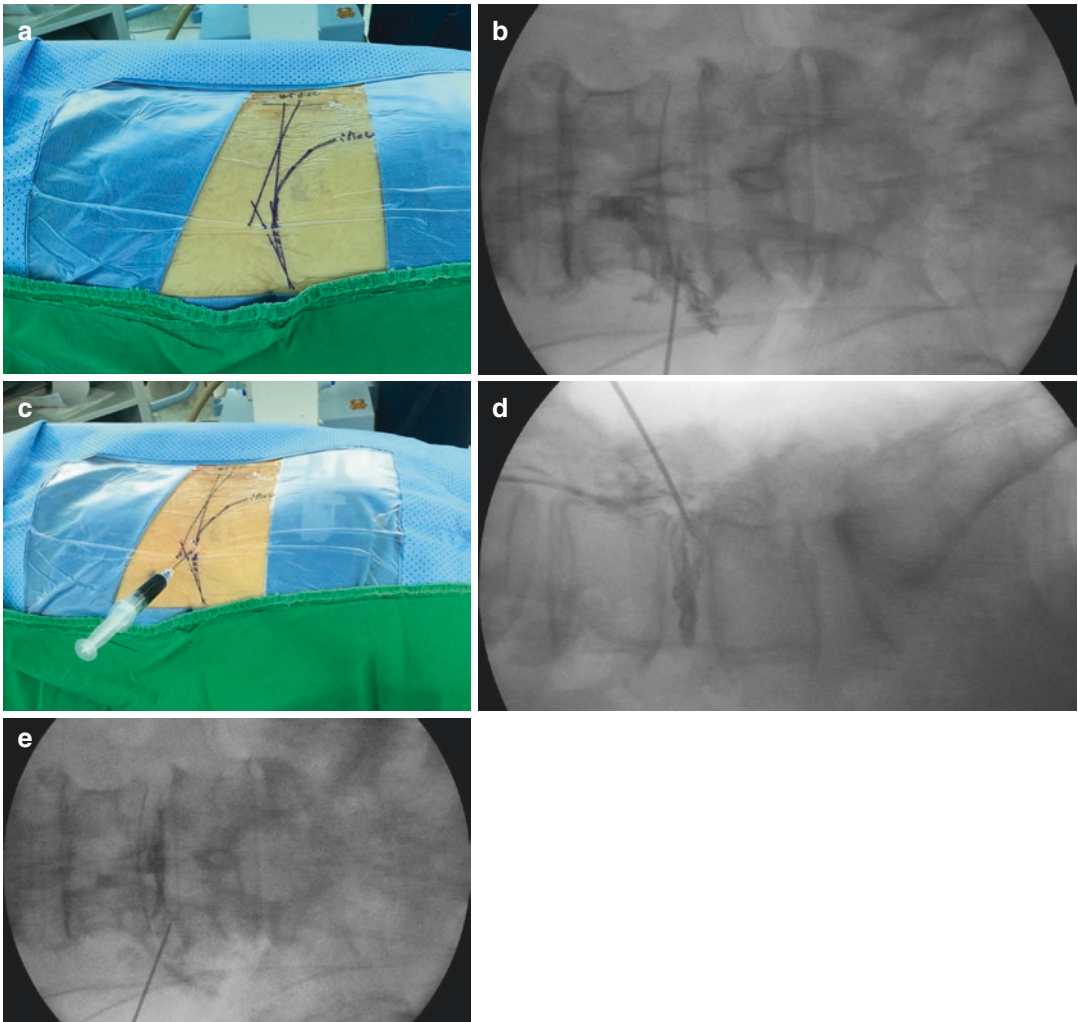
Surgical steps (a) skin entry point, (b) epidurogram, (c, d) discography, and (e) intraoperative radiography revealing initial targeting for downward migrated disc herniation
